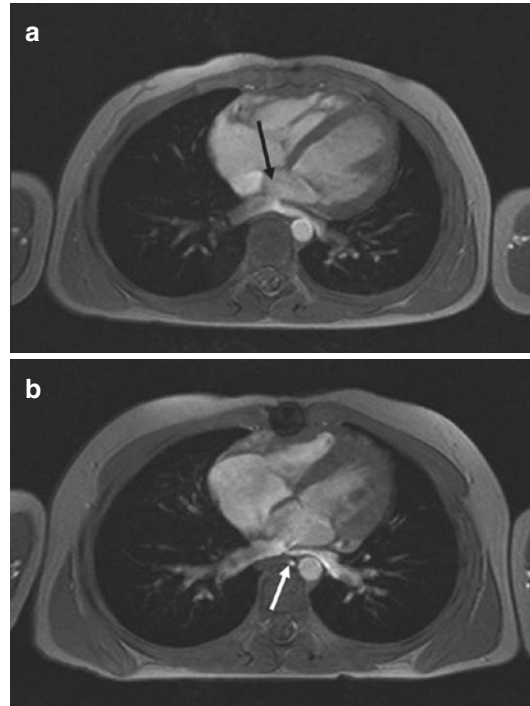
Postoperative pulmonary venous obstruction after surgical repair of total anomalous pulmonary venous return at MRI. (a) MRI realized one month after repair. Four-chamber view image obtained from cine FLASH MRI sequence demonstrates a large anastomosis between the left atrium and the pulmonary vein confluence (*black arrow*) and good size of pulmonary veins. (b) MRI realized four months after repair. Four-chamber image obtained from cine FLASH MRI sequence demonstrates a progressive stenosis on the left pulmonary vein near the venoatrial anastomosis (*white arrow*)
